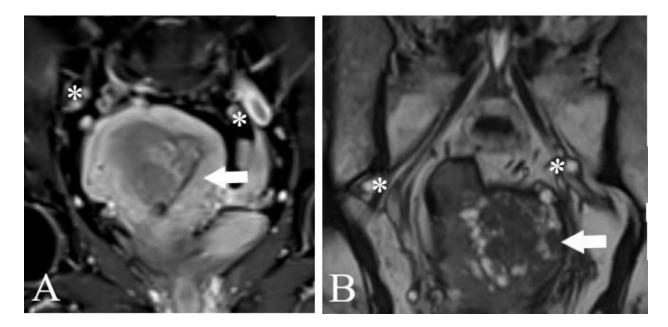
MR imaging A. Cervical cancer, tumour spread to upper third of vagina and rectum (T2 sequence, sagittal view)
